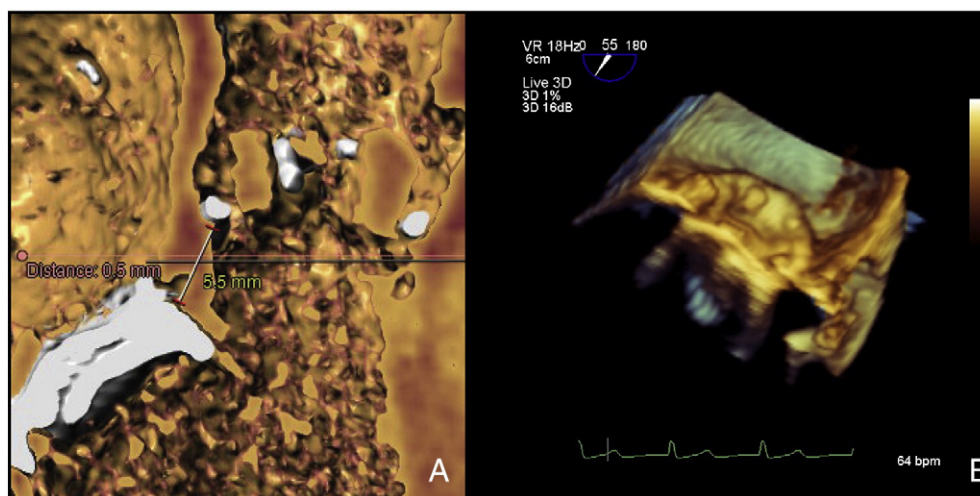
Multislice cardiac computed tomography (A) and 3D echocardiographic reconstruction (B) showing the distance between the aortic annulus and the mitral valve housing.
